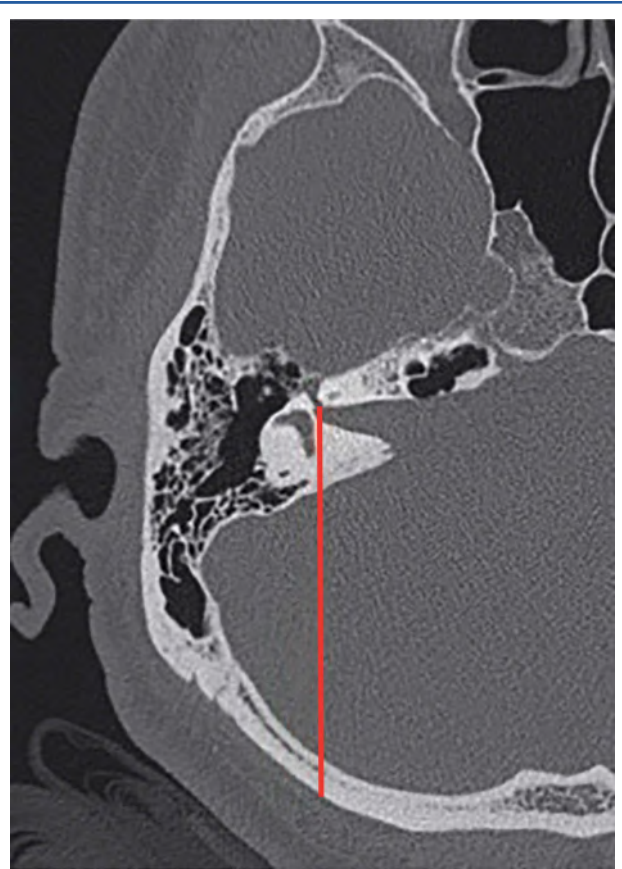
Bone window axial CT. The FLL line starts at the orifice of the fallopian canal and proceeds backward tangentially to the posterior semicircular canal: axial CT scan showing the FLL (in red). CT, computed tomography; FLL, fundus–labyrinth line.
